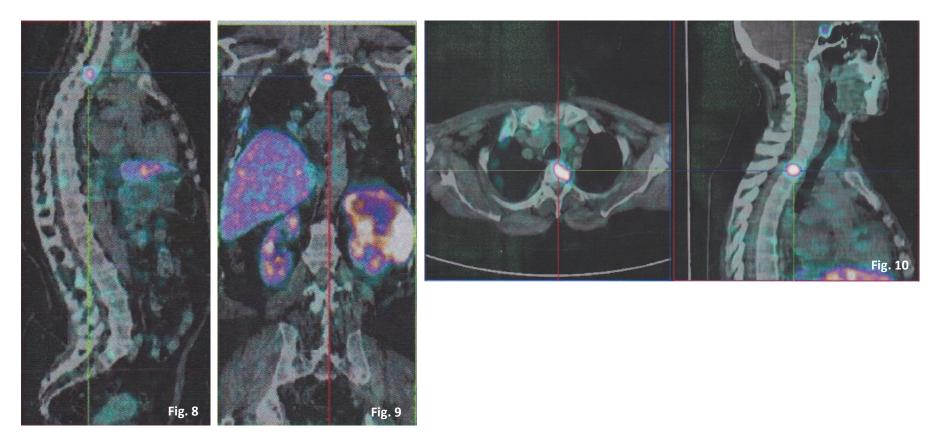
68-Ga DOTATATE PET/CT
